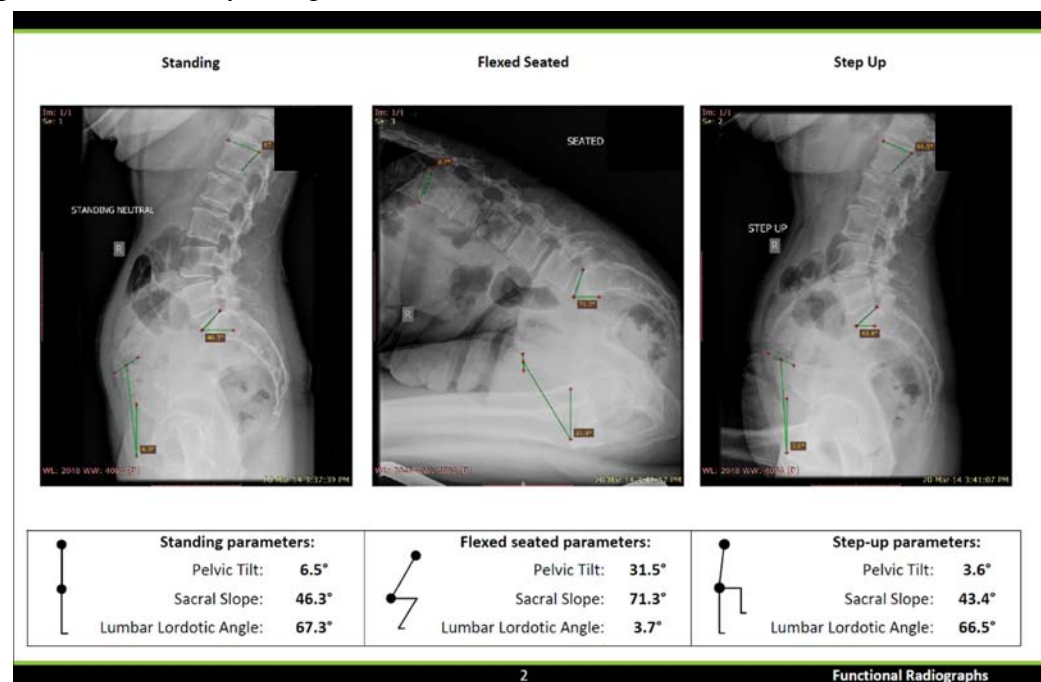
The functional pelvic tilt, sacral slope and lumbar lordotic angles are measured from three lateral functional radiographs: standing, flexed seated and step-up.
